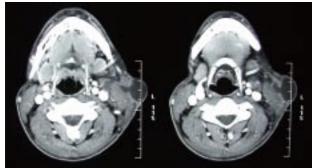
Cervical CT scan before antibiotic therapy.
